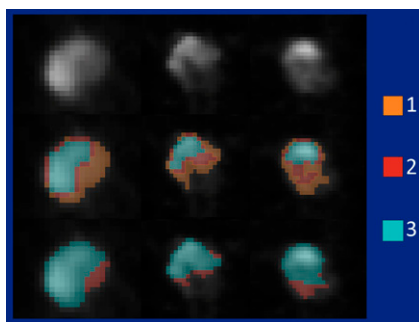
Artificial intelligence (AI) tool for detection and quantification of primary prostate tumors, bone metastases, and lymph node lesions in PSMA PET/CT. Images show ^{68}Ga -PSMA PET foci (top row) on the prostate in (left to right) axial, coronal, and sagittal views. Middle row depicts manual annotation without AI assistance. Bottom row depicts manual annotation with AI assistance. Orange pixels were annotated by only 1 reviewer; red by 2; and blue by all 3.
